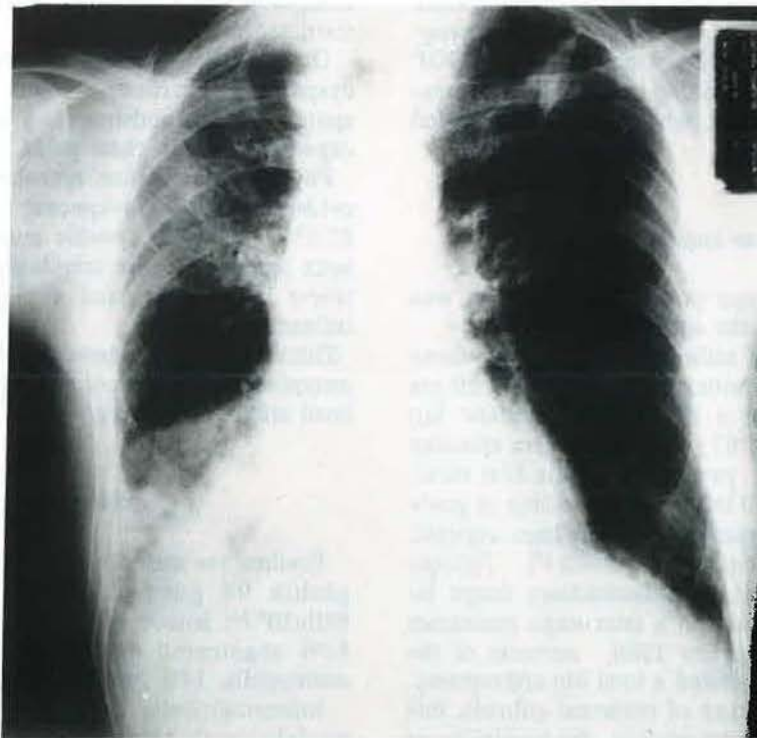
Chest radiograph on admission.
